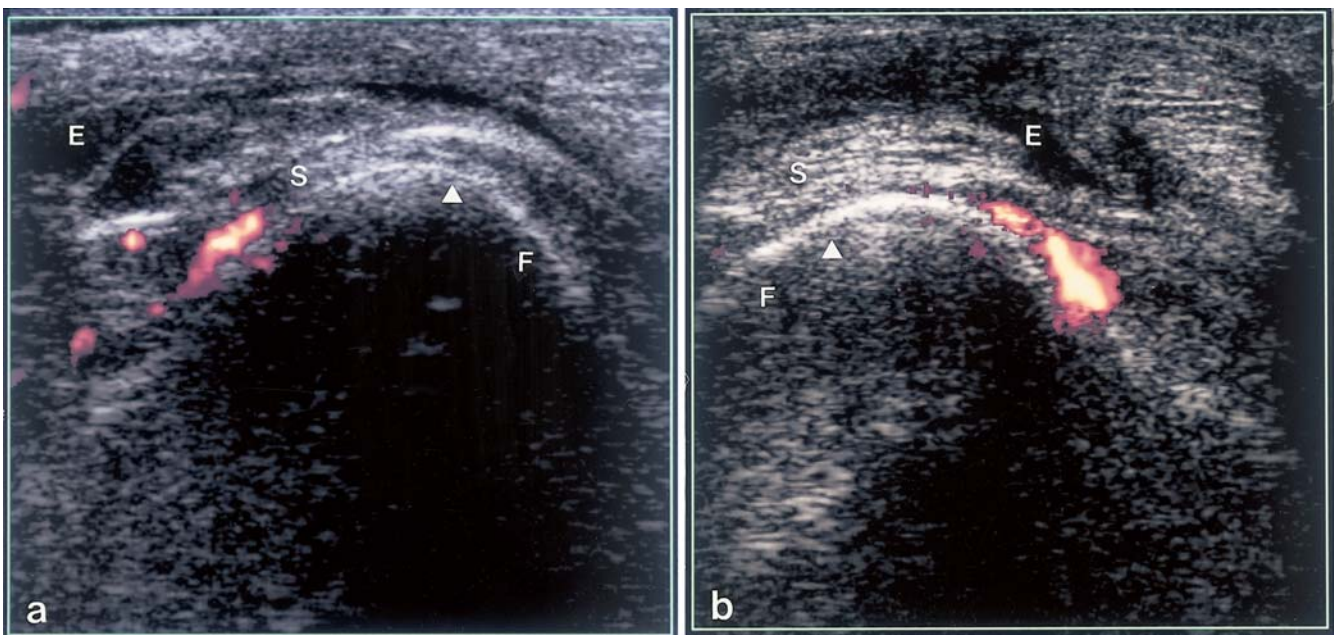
Power Doppler sonographs. a Supracortical vascularization with grade 2 intensity observed on a transverse scan at the suprapatellar aspect of the right knee of a 33-year-old male patient with CRP at
